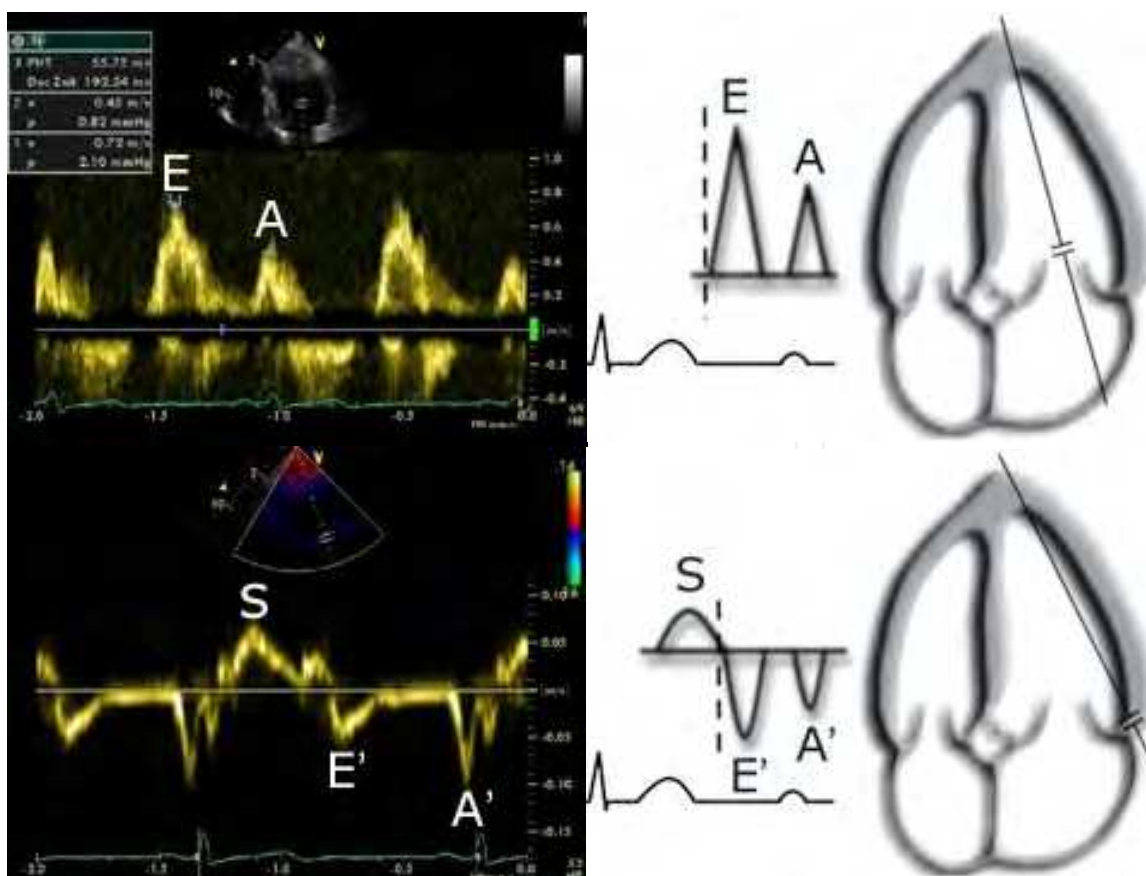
Transmitral Doppler (top) and tissue Doppler (bottom) allowing quantification of the early diastolic peak filling velocity (E) and early diastolic peak velocity of the mitral annulus (E'). The ratio  $E/E'$  is used to determine diastolic dysfunction.
